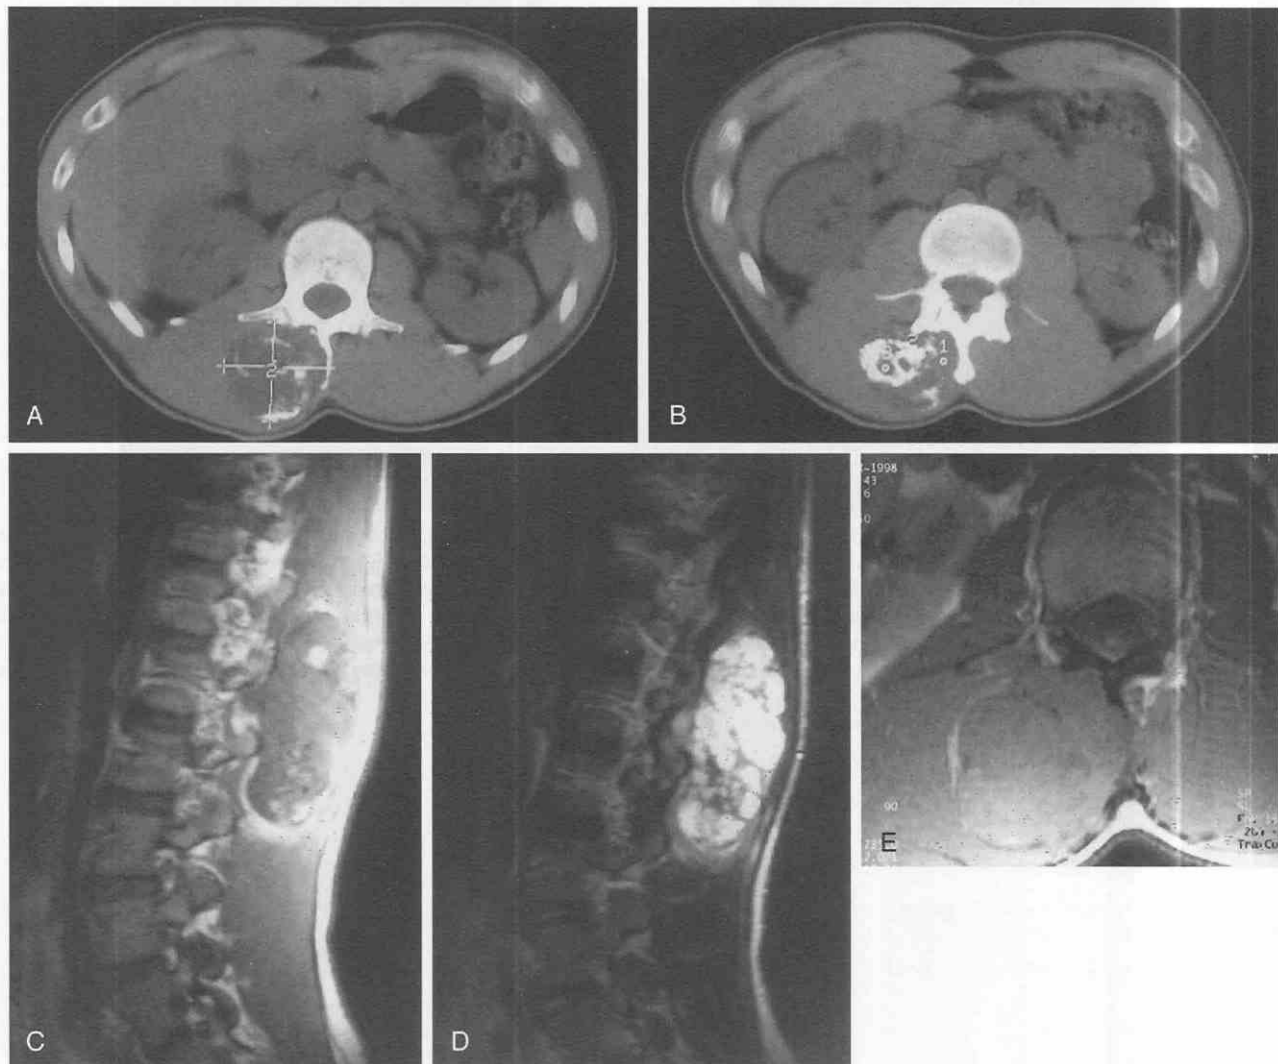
A, Axial CT image demonstrating an osteochondroma that involves the posterior elements of the L1 vertebral body. This mass is not in the typical C2 location, and it is larger than usually seen. There is no definite continuity of cortex and marrow between the mass and L1. B, Axial CT image of L1, showing the same mass with scalloping of the right aspect of the spinous process and calcification within the mass. C, T1-weighted sagittal image to the right of midline. The osteochondroma is mixed in signal intensity. D, T2-weighted image of the lumbar spine shows the same mass having mixed signal intensity. This is a nonspecific appearance. E, T1-weighted axial image of the lumbar spine showing that the mass has mixed signal intensity and does not involve the spinal canal.
